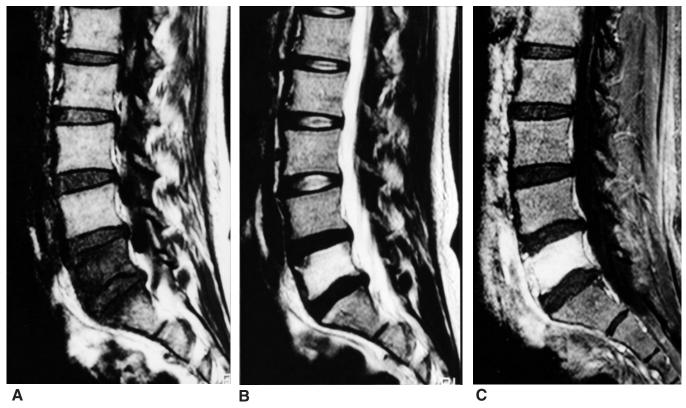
Sagittal MR images of the lumbar spine. T1 weighted image shows diffuse hypointensity in L5 and focal hypointensity in the S1 (A). T2 weighted image shows diffuse hyperintensity in L5 and focal hypointensity in the anterosuperior corner of the L5 vertebral body. L4/5 and L5/S1 disc spaces show hypointensity (B). Postcontrast T1 weighted image shows enhancement of L5 and paravertebral soft tissues anterior to L4 and L5 (C).
